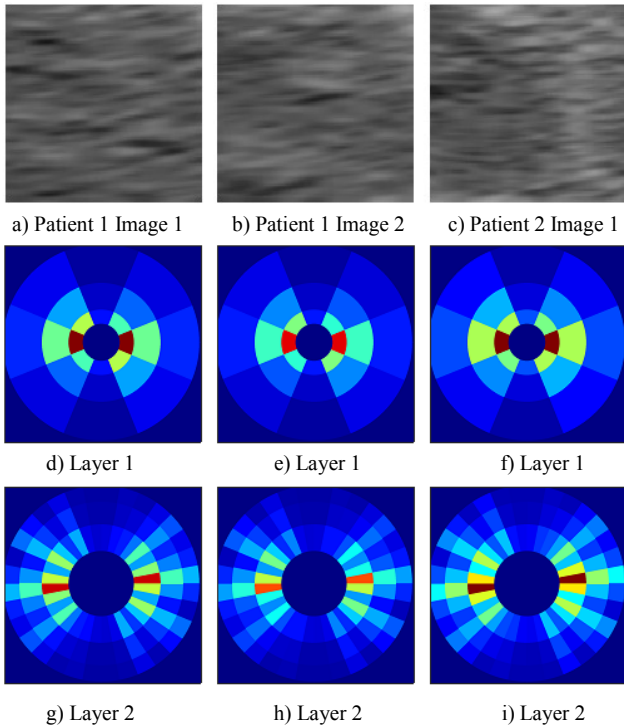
Three ultrasound images of a clot taken from two different patients; the first and the second layers of the scattering coefficients are represented in the frequency plane.
